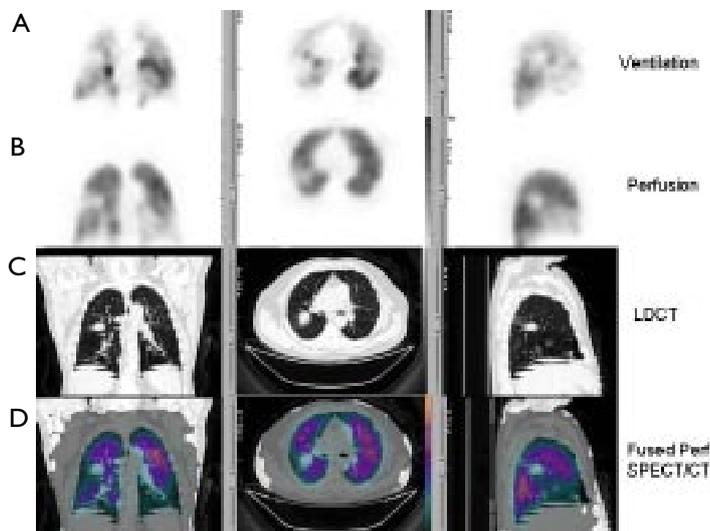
V/Q SPECT/CT scan confirms a RML lung cancer as the cause of the perfusion defect. (A) Ventilation SPECT and (B) Perfusion SPECT demonstrating a matched defect in the RML, (C) with a corresponding RML lung tumour identified on LDCT. (D) Fused SPECT/CT images confirm these findings.
